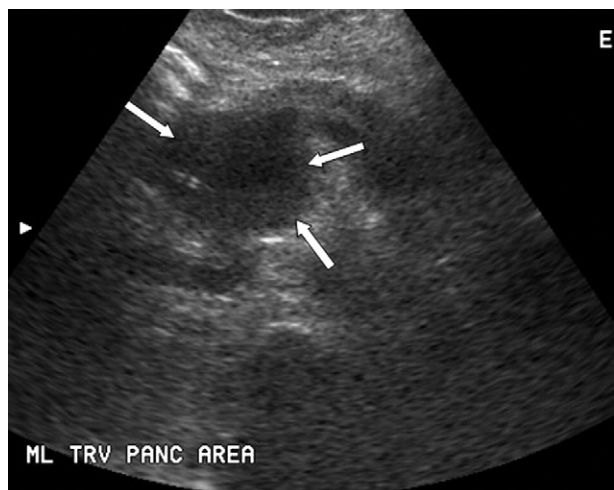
Transverse ultrasound image of the pancreas shows a hypoechoic mass in the region of the head (arrows) with mild through transmission of ultrasound beam.
